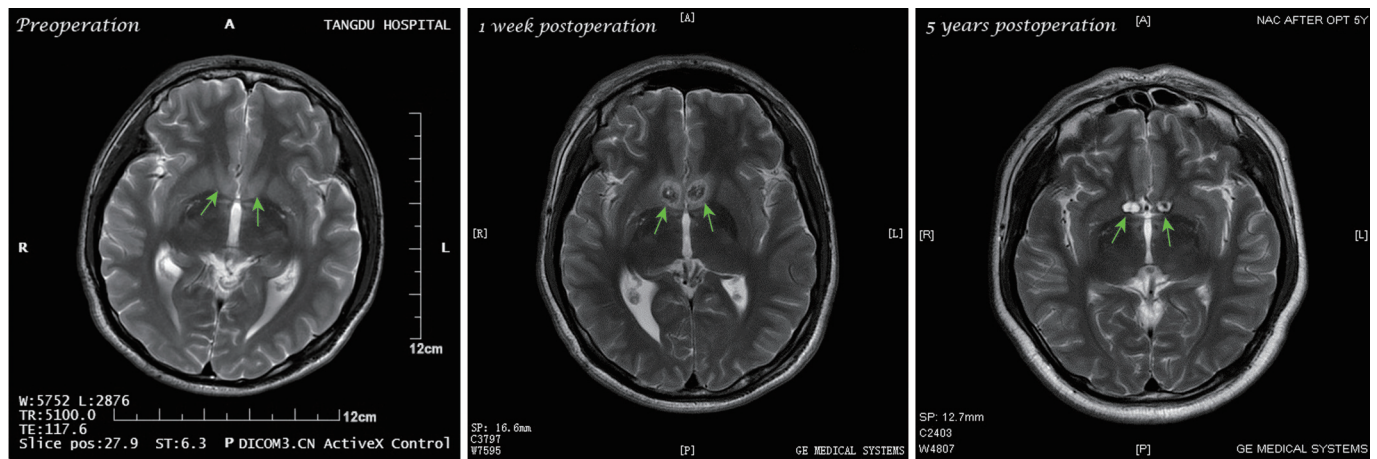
The axial view MRI of the surgery opiates-dependent patients. The place marked by the arrow is the proximal NAC.
